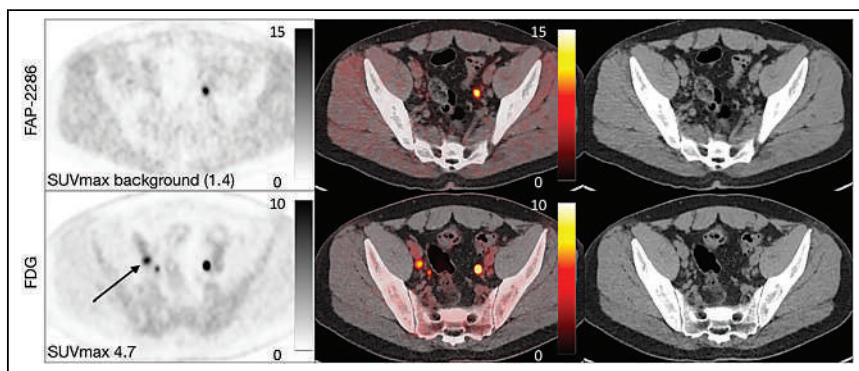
^{68}Ga -FAP-2286 and ^{18}F -FDG PET (left), PET/CT (middle), and CT (right) in 28-y-old man with non-MIBC. ^{18}F -FDG PET showed positive nodes concerning for metastatic disease, whereas ^{68}Ga -FAP-2286 PET showed no uptake. Lymph node dissection confirmed absence of cancer in lymph nodes. Avidity seen on ^{68}Ga -FAP-2286 PET is from excretion of tracer into left ureter.
